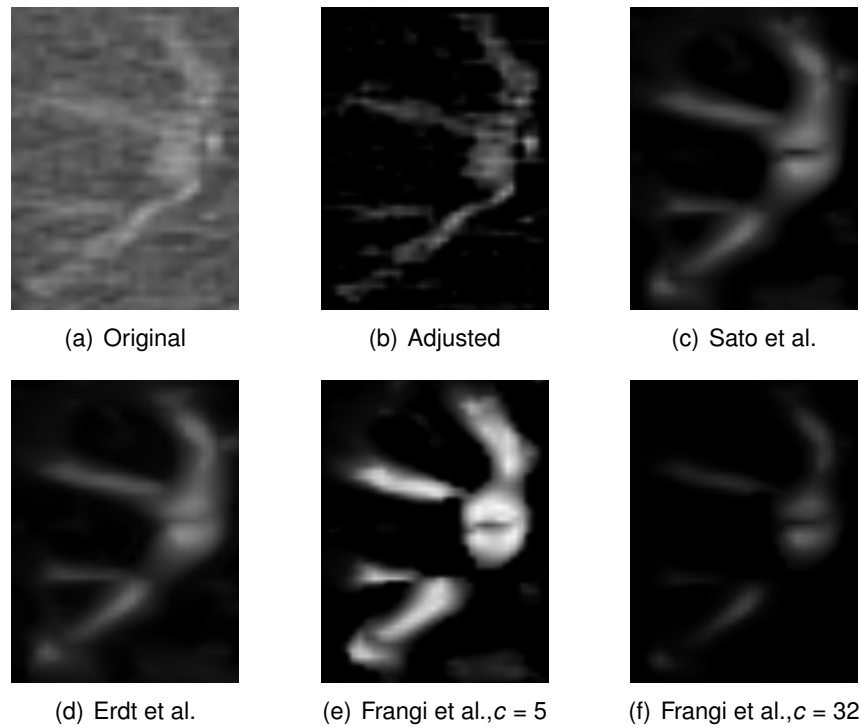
Comparison using a CT dataset of the liver. (a) Representative detail of the liver from a CT dataset. (b) The same detail with a different window leveling. Results using filter functions by (c) Sato et al., (d) Erdt et al., (e) Frangi et al. with $c = 5$ and (f) Frangi et al. with $c = 32$. Image taken from [DOL10a].
